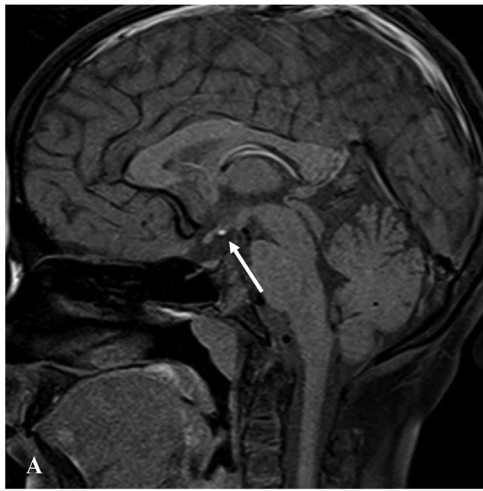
A 24-year-old female patient presented with hypothyroidism and obesity. Growth hormone and thyroid-stimulating hormone (TSH), T3, and T4 deficiency was identified on hormone analysis. Sagittal magnetic resonance imaging (MRI) image demonstrating ectopic T1-weighted (T1W) bright spot, located at the median eminence with absence of infundibulum.
